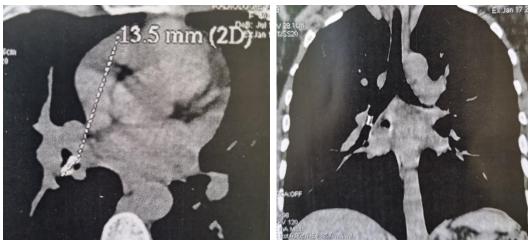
Chest CT scan: a calcified foreign body in the right intermediate bronchus
